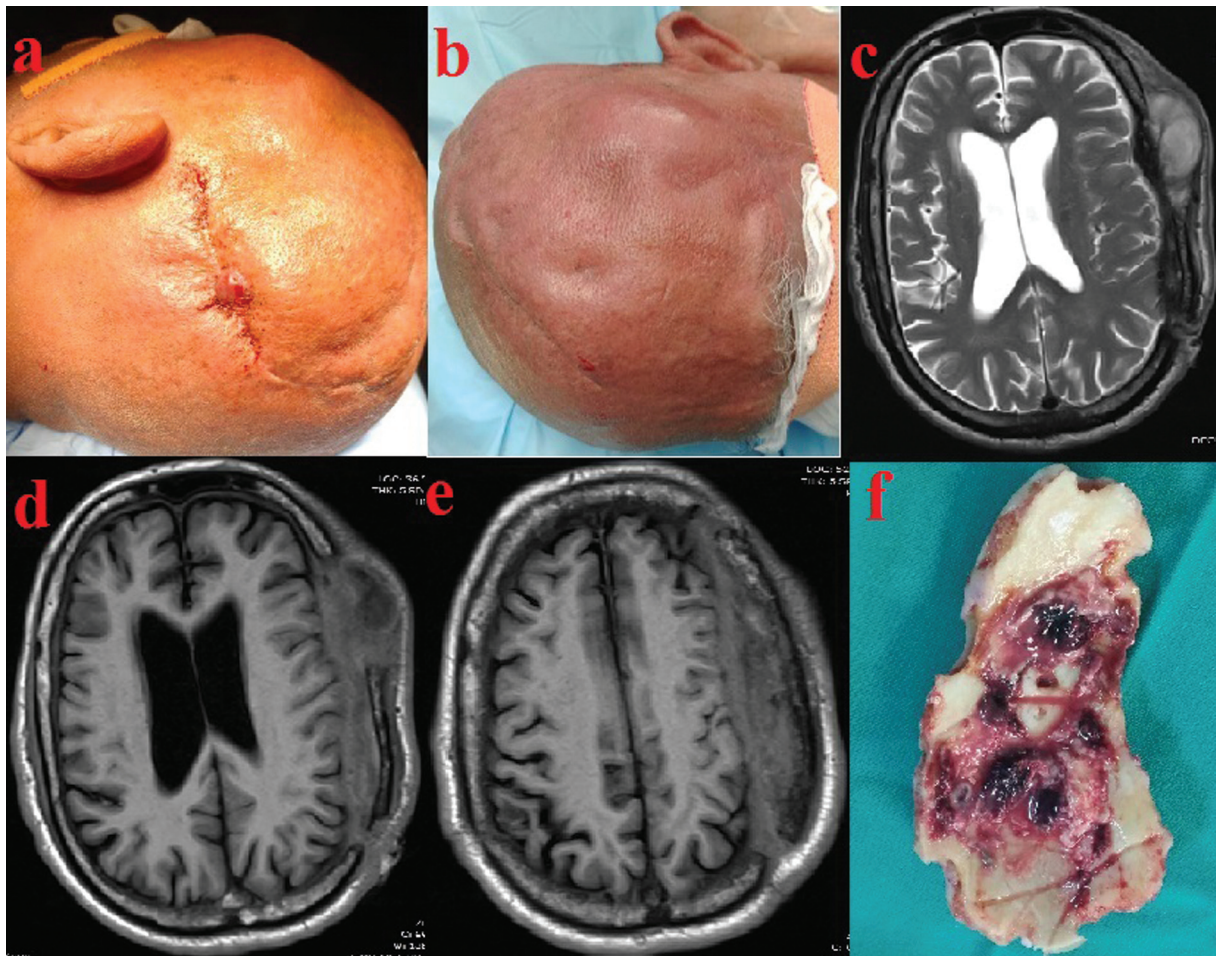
Clinical photographs (A, B) of a patient with delayed wound infection 8 months after the cranioplasty showing granulation tissue with discharge at the incision site; noncontrast MR imaging (C–E) showing liquefied collection outside and granulation tissue inside the replaced bone flap and (F) clinical image of the osteomyelitic eroded bone flap.
